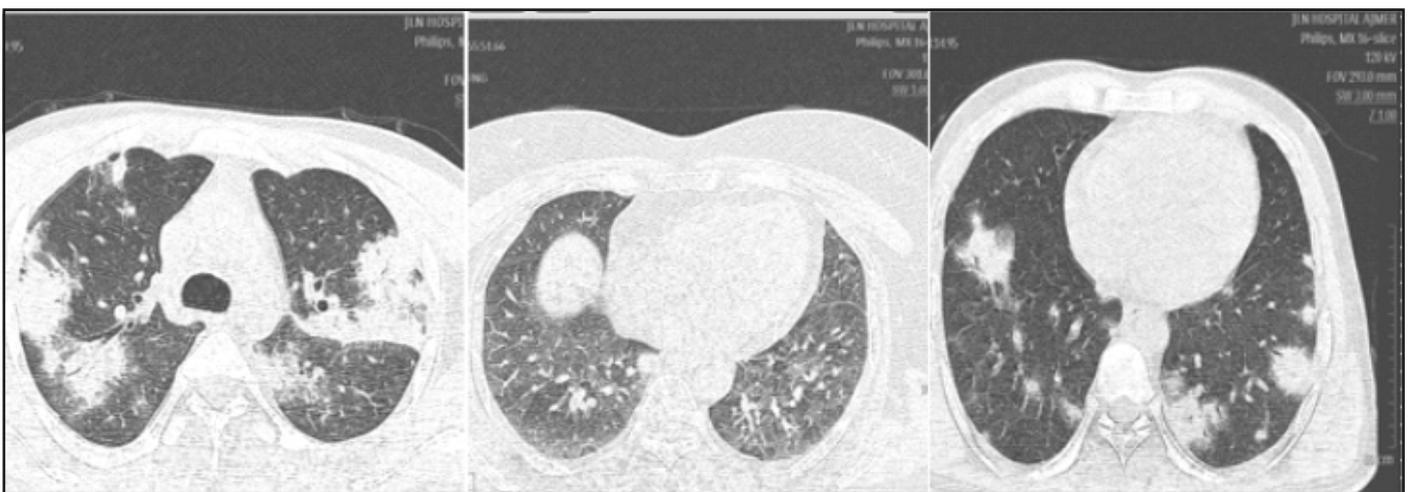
CT images of patients with COVID-19 pneumonia in bilateral lung. Axial thin-section CT images show multiple lesions of pure GGO, GGO with consolidation, GGO with reticular and/or interlobular septal thickening, and air bronchogram (arrow) in lesion.
